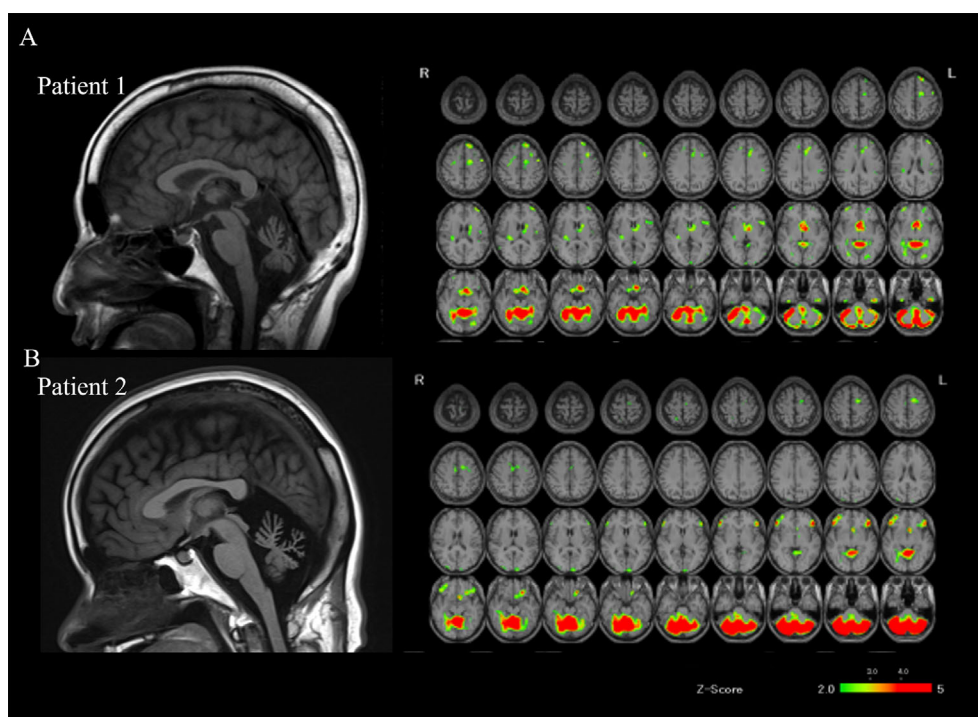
Brain MRI and ^{99m}Tc -ECD SPECT. T1-weighted images indicating atrophy in the cerebellar hemispheres and cerebellar vermis in patient 1 at 64 years of age (A) and in patient 2 at the 42 years of age (B). eZIS analyses using ^{99m}Tc -ECD SPECT revealed reduced cerebellar blood flow in both of the patients. eZIS: Easy Z-score imaging system, ECD: ethyl cysteinate dimer, MRI: magnetic resonance imaging, SPECT: single-photon emission computed tomography
